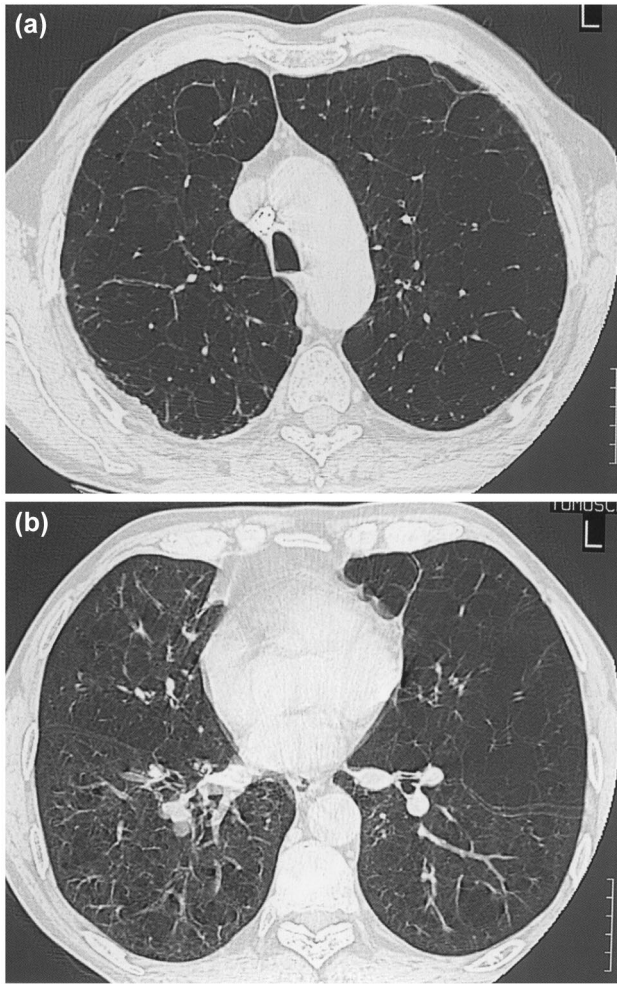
High resolution CT scans showing heterogeneous emphysema. (a) ES: left = 4; right = 4. ES: (b) left = 3; right = 2. DHT = 1.5, ARE = 1.1. Bilateral RP, Δ FEV₁ = 0.52 l.
